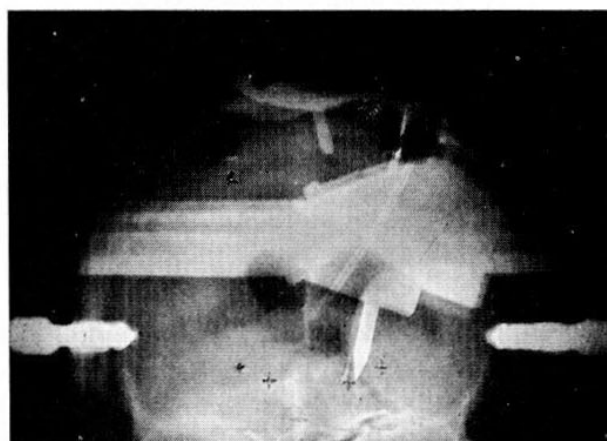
Superposition of the postero-anterior roentgenogram of the same case as Fig. 7. This is not the case shown in Figs. 5 and 6.
